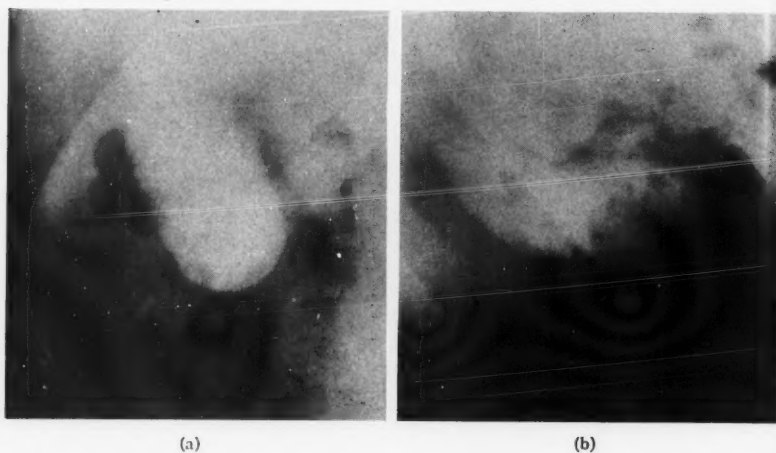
Cholelithiasis. (a) Posteroanterior prone roentgenogram. Although calculi are present they cannot be distinguished from the superimposed gas shadows. (b) Posteroanterior lateral decubitus roentgenogram showing multiple small nonopaque calculi which have settled to bottom of gallbladder silhouette and stand out in sharp contrast to surrounding bile above although the obscuring gas still lies over gallbladder.
